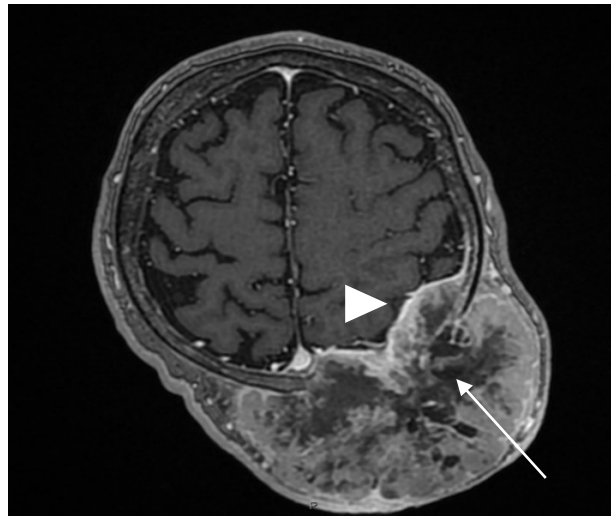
Magnetic resonance imaging of the brain. Transversal 3DT1W images after paramagnetic contrast administration. Prominent inhomogeneous signal alteration of the lesion with extensive zones of hypovascularity suggesting necrosis (indicated by →). Signs of dural infiltration (indicated by ►). The lesion is localized near the displaced superior sagittal sinus with no evident contrast defect. 3DT1W – 3D T1 weighted image.
